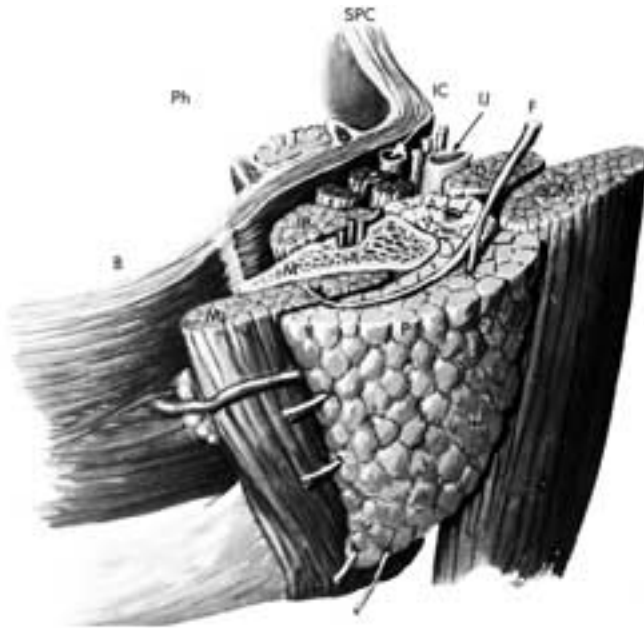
Normal anatomy of the left parotid gland and the parapharyngeal space viewed obliquely and from above. Note how the deep portion of the parotid gland extends behind the ramus of the mandible and in front of the sternocleidomastoid muscle and the posterior belly of the digastric muscle. Pharynx (*Ph*), superior pharyngeal constrictor muscle (*SPC*), tonsil (*T*), buccinator muscle (*B*), masseter muscle (*Ms*), sternocleidomastoid muscle (*SCM*), posterior belly of the digastric muscle (*D*), internal pterygoid muscle (*IP*), mandible (*M*), internal carotid artery (*IC*), internal jugular vein (*IJ*), parotid gland (*P*), facial nerve (*F*), external carotid artery (*A*), posterior facial vein (*V*). The combined CT-sialogram. (From Som PM, Biller H. *Radiology* 1980;135:387–390.)
